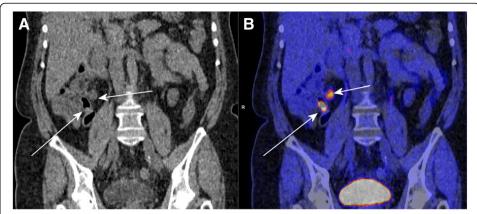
After oral administration of 75 mg carbidopa, 300 MBq of ¹⁸F-FDOPA was injected intravenously. Images were acquired 60 min after injection on a 64-slice PET/CT camera (mCT Biograph, Siemens Medical Solutions, Knoxville, TN USA,) whole body. Increased uptake was noted in the terminal ileum (left arrow) and in the mesentery (right arrow), as shown in figure 1a (CT only) and 1b (fused PET/CT images)
